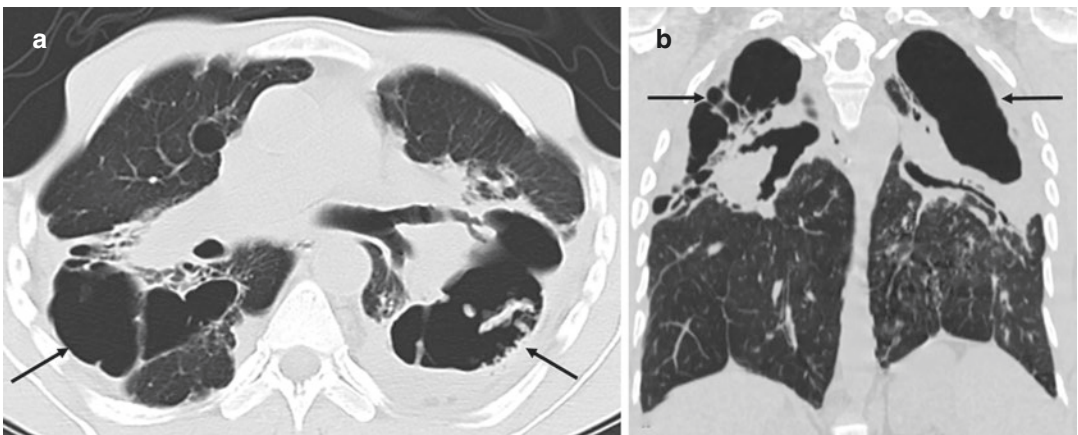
Cavitating sarcoidosis mimicking tuberculosis sequelae. (a) Axial and (b) coronal CT images show bilateral cavitating consolidations of the upper lobes and the upper segments of the lower lobes with bronchiectasis (arrows)
